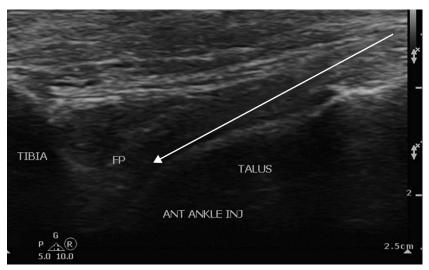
Sonographically guided injection of the ankle joint, long axis to joint, needle in plane with transducer. Arrow delineates path of needle. Left, proximal; right, distal.
